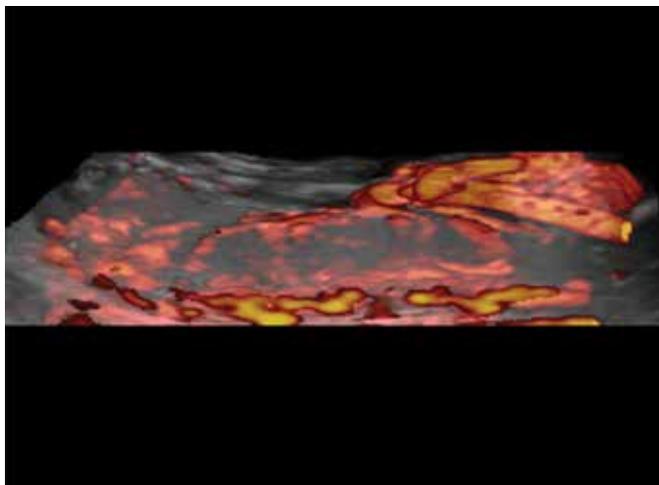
Three-dimensional power Doppler of the normal placental vasculature and umbilical cord insertion in the second trimester of pregnancy shown in transparent mode
